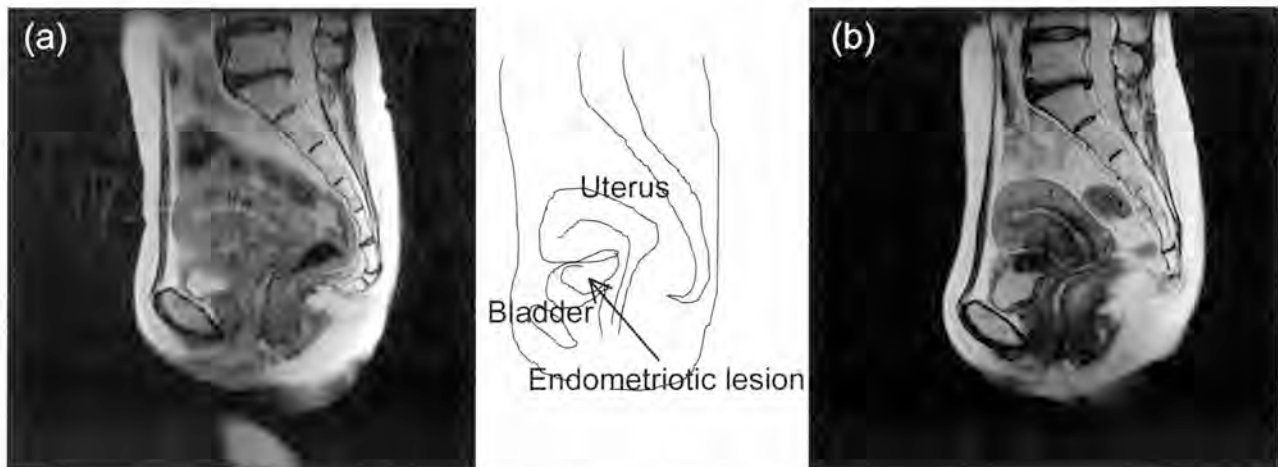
Sagittal T2-weighted MR images before (a) and after (b) dienogest therapy.
